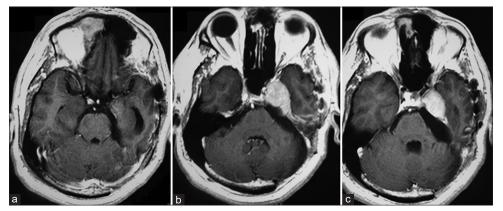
(a-c) Magnetic resonance imaging at the post operated showed parcial resection of the left petroclival tumor with remaining lesion in the middle fossa. Axial gadolinium-enhanced image.
